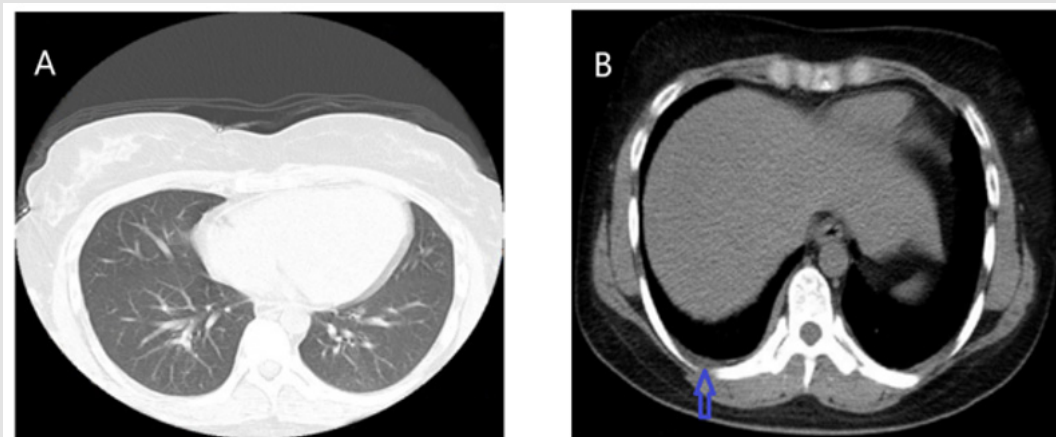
CT scan of the chest of the patient (2012-09).
